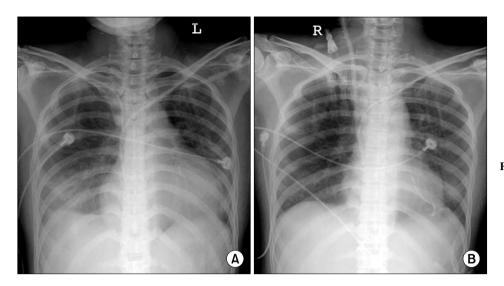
Chest radiograph showed waterbottle shape cardiomegaly (cardiothoracic ratio 64%) before pericardiocentesis (A). Chest radiograph showed improvement of cardiomegaly (cardiothoracic ratio 51%) after pericardiocentesis (B).
